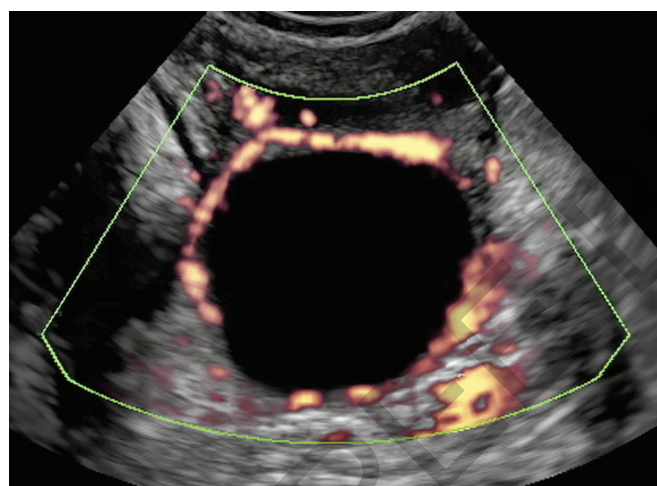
Perifollicular vascularity seen on color Doppler.
